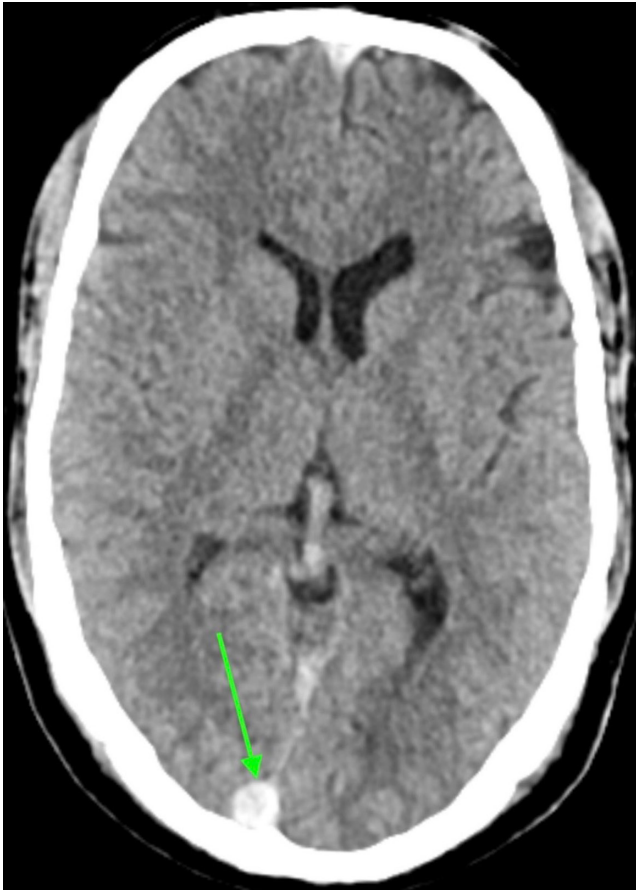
Dense delta sign visualized in non-contrast enhanced CT of the patient; signifying sagittal sinus thrombosis.
